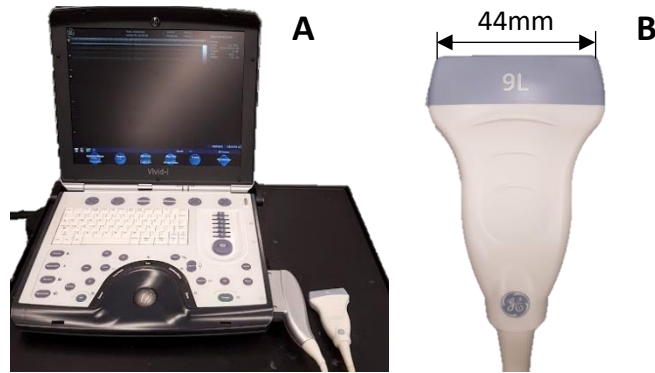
A: GE Vivid i ultrasound unit. B: GE 9L 2.5-8MHz linear transducer.
